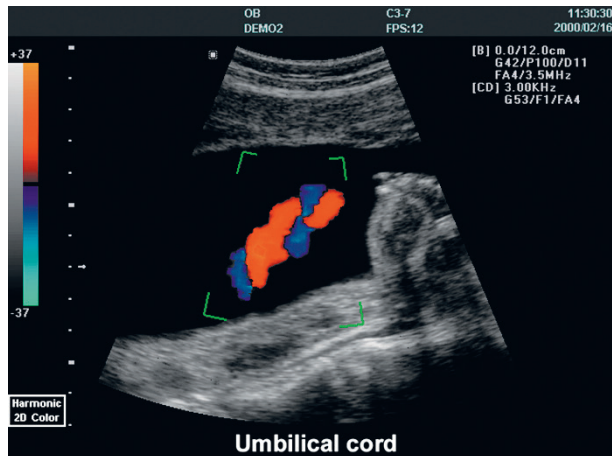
Twisting of umbilical vessels. Ultrasound color flow mapping
